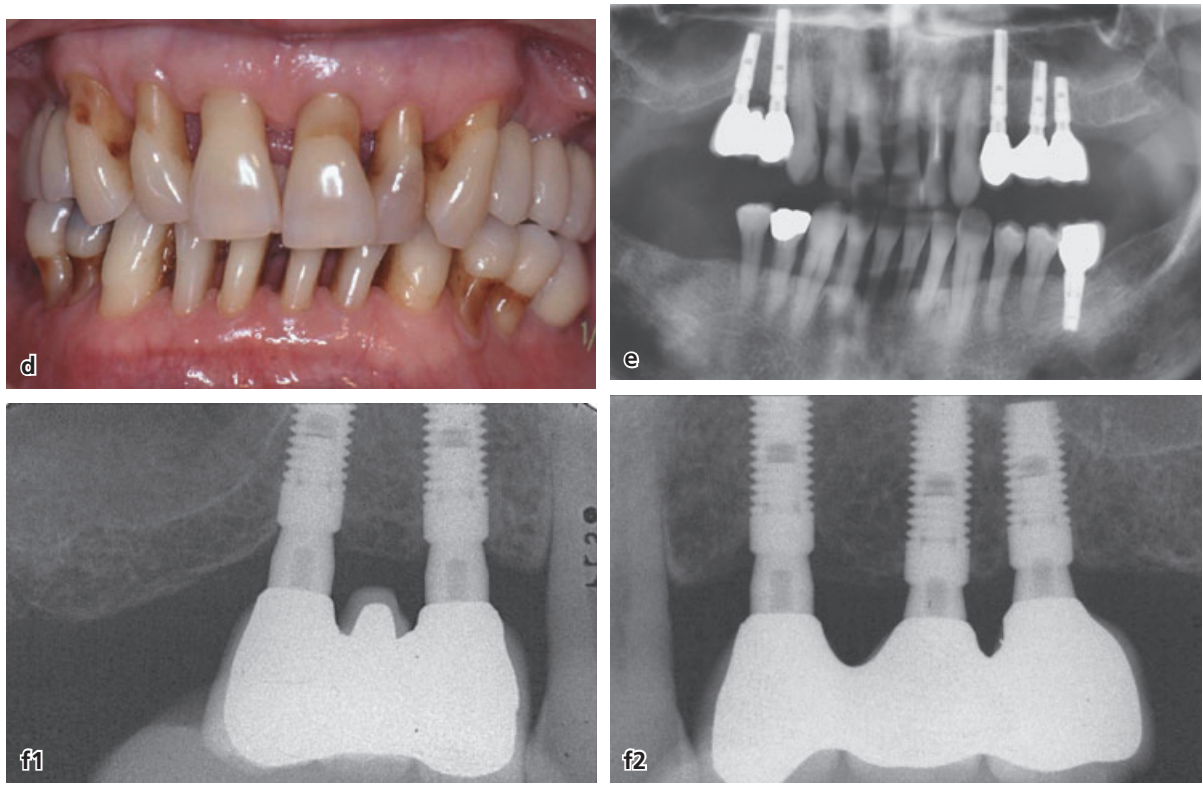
(d-f) Clinical and radiographic status of patient H.L. after completion of the implant treatment.
